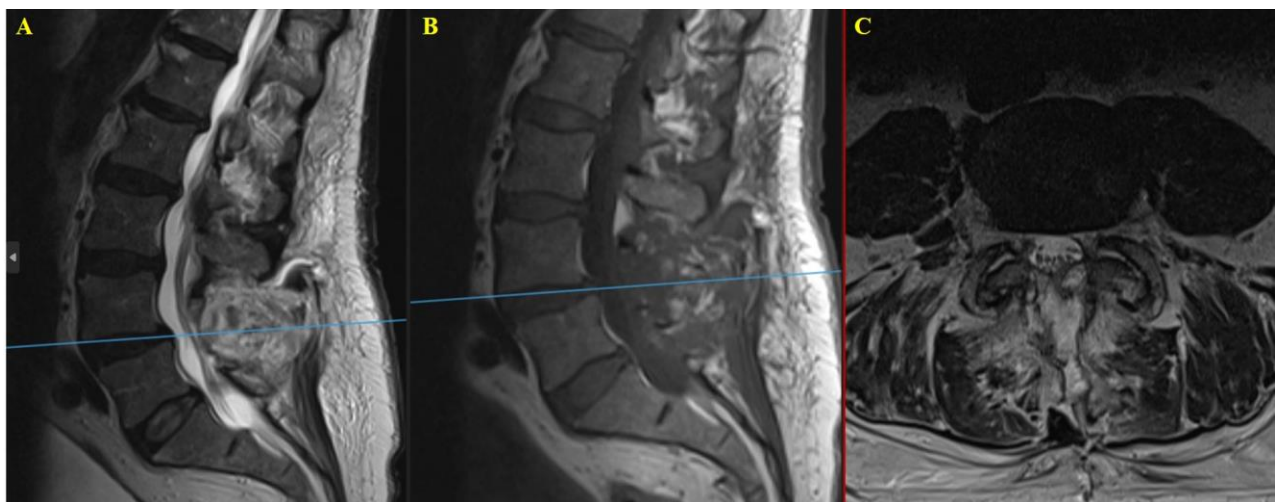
Post-operative MRI showing adequate decompression of the dorsal thecal sac and cauda equina.
